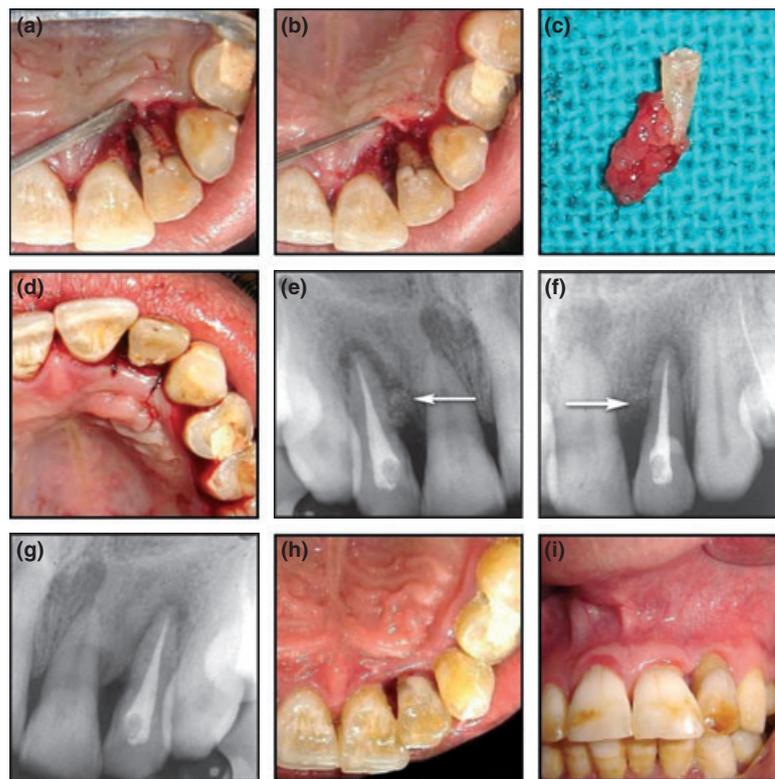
(a) Surgical opening of radicular lingual groove. (b) Tooth appearance after root resection. (c) Resected root along with apically attached granulation tissue. (d) Suturing. (e) Postoperative radiograph showing bone graft in place (arrow). (f) Postoperative radiograph at 3 months, the arrow points to the filling in of the lateral defect. (g) Postoperative 1-year radiograph. (h) Postoperative 1-year clinical photograph palatal view. (i) Buccal view clinical photograph showing gingival recession over the surgical area 1 year after treatment.
